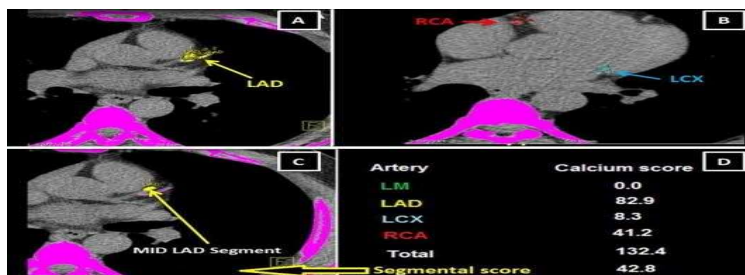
Axial CT cuts showing CT calcium scoring.
